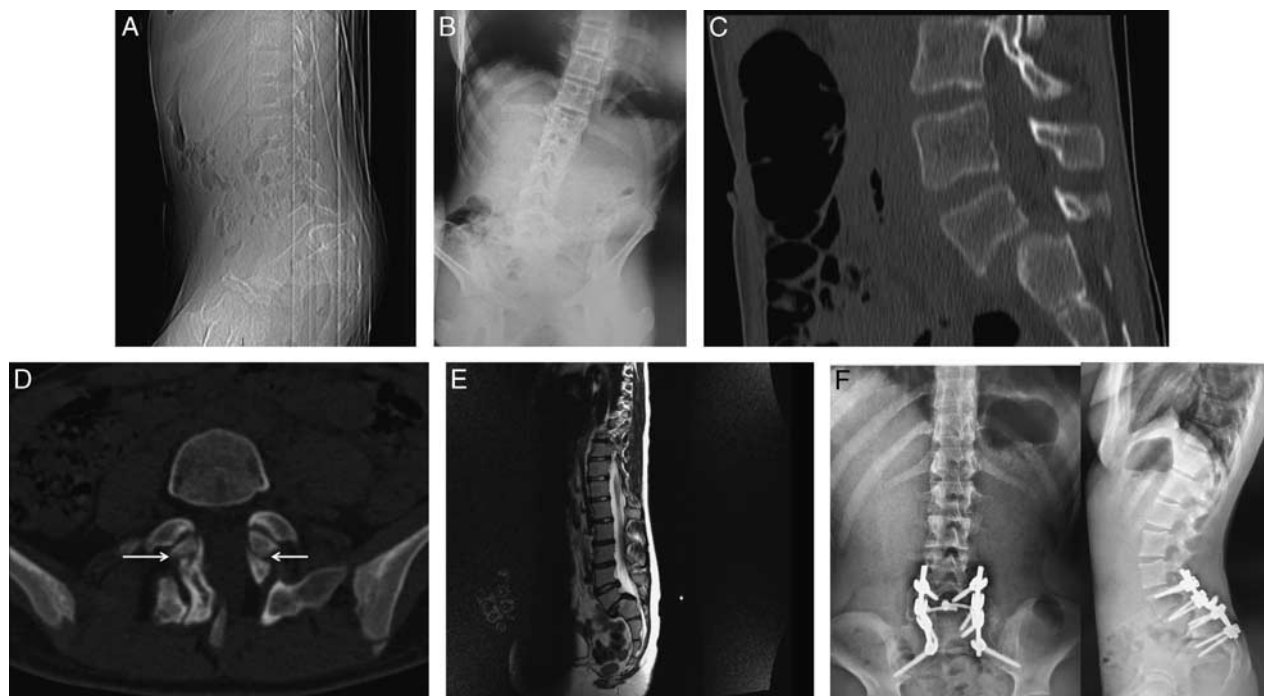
A, Preoperative lateral radiograph of the lumbosacral spine of case 4 aged 12 years at initial presentation showing a grade III spondylolisthesis of L5/S1. Note the vertical orientation of the sacrum indicative of the pelvic tilt. This is evident on the preoperative kinematics of gait analysis (Fig. 2A). B, Preoperative postero-anterior radiograph of case 4 at initial presentation. Mild scoliosis is seen. C, Lateral mid-sagittal CT scan image of case 4 preoperatively revealing a grade III spondylolisthesis. The vertical orientation of the sacrum is once again evident. D, Axial CT scan image at the level of L5/S1 in Case 4 showing the presence of bilateral pars defects associated with the spondylolisthesis in this patient (highlighted by solid arrows). This was noted in 2 of the 4 patients. The remaining 2 had an elongated pars. E, Preoperative mid-sagittal T2-weighted magnetic resonance imaging scan image of the spine in case 4 revealing narrowing of the spinal canal at the level of the spondylolisthesis. There were no neurological symptoms. F, Postoperative PA and lateral radiographs of the patient at 24 months postoperative follow-up showing good fusion with no loosening of metalwork. The grade of spondylolisthesis has improved from III to I.
